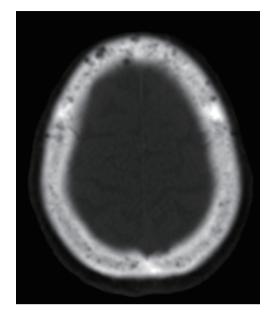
Multi-detector computed tomographic axial image (bone window) at the level of the skull vault that demonstrates small, round, multiple, well-circumscribed lytic bone lesions and diffuse osteopenia.
